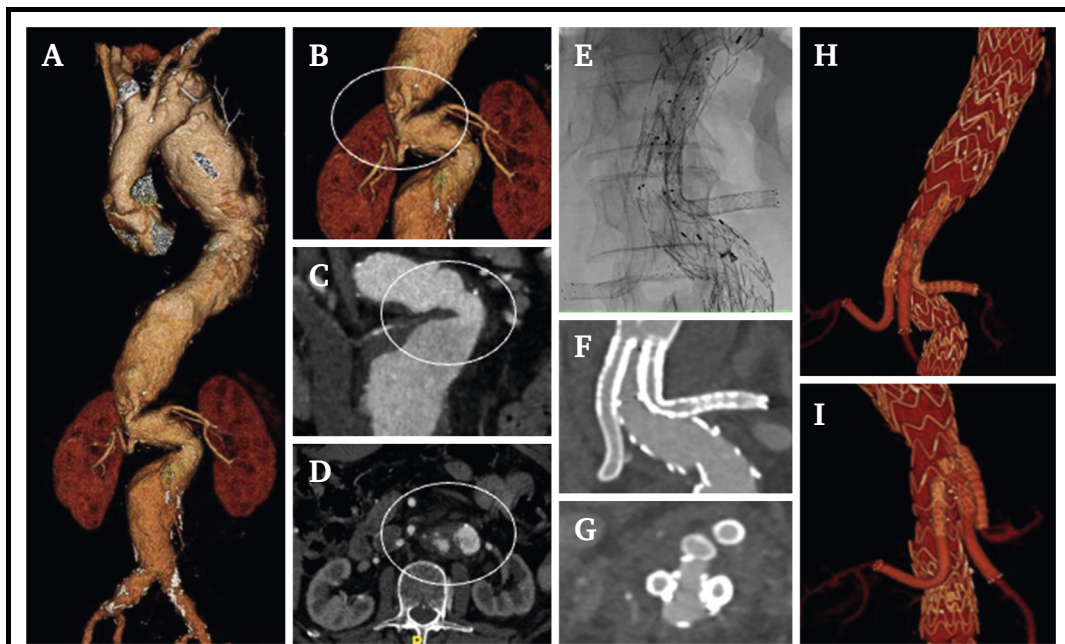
Urgent case of extent II thoracoabdominal aneurysm treated in a urgent setting by E-side endografting. Patient with (A) extent II thoraco-abdominal aortic aneurysm and (B – D) complex anatomy in the paravisceral segment, with an 18 mm narrow and angulated aorta (white circle). (E) Intra-operative images showing adequate E-side endograft and branches geometrical conformation. (F, G) Post-operative computed tomography angiogram (CTA) demonstrating patency of renal branches with no kinking or compression (F) and good conformability at the narrowest aortic level in the axial images (G). (H, I) 3D reconstruction of the post-operative CTA showing graft and branches adaptability to this complex anatomy in anteroposterior view (H) and lateral view (I).
